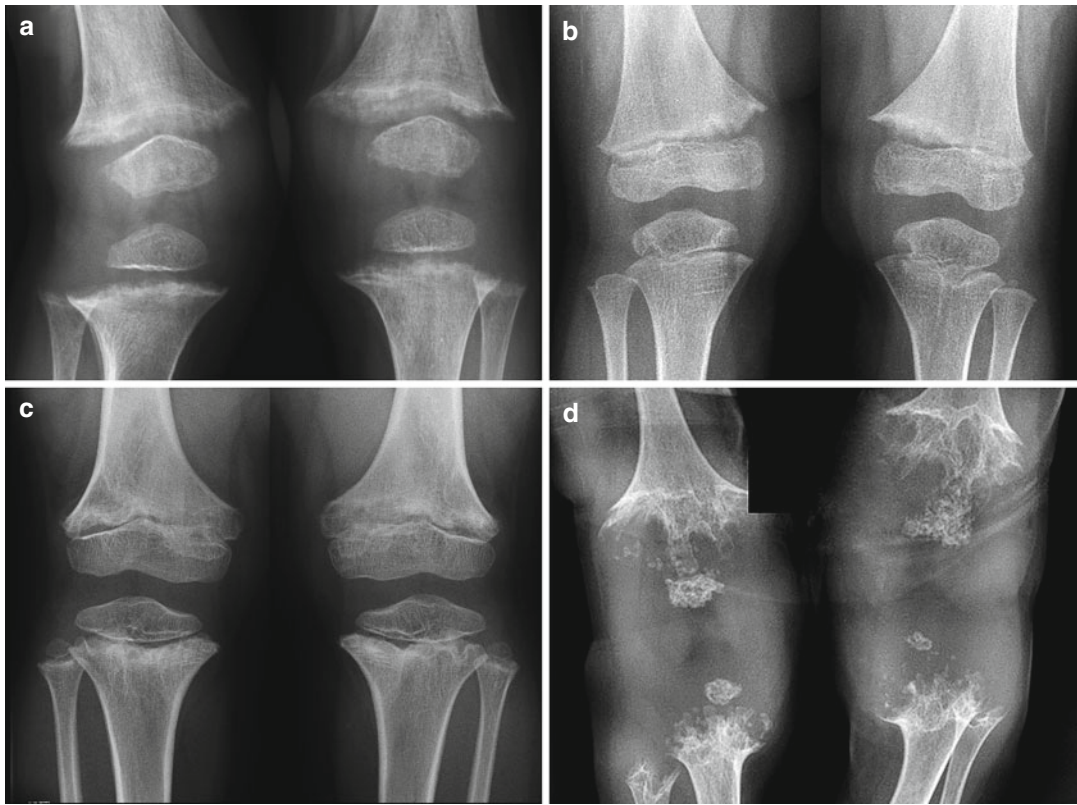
Radiographs of the knee showing similar metaphyseal changes with different pathogenesis. (a) Renal tubular acidosis with rickets: low serum phosphate and acidosis impair the mineralization of the bone tissue that is newly deposited at the growth plate. There is also osteopenia of the adjacent bone structures. The image is typical for all forms of rickets. (b) Spahr metaphyseal dysplasia (MMP13 mutations): the metaphyseal fraying is probably caused by an impairment in the resorption of cartilage matrix. (c) Cartilage-hair hypoplasia (RMRP mutations): the metaphyseal irregularities may resemble
